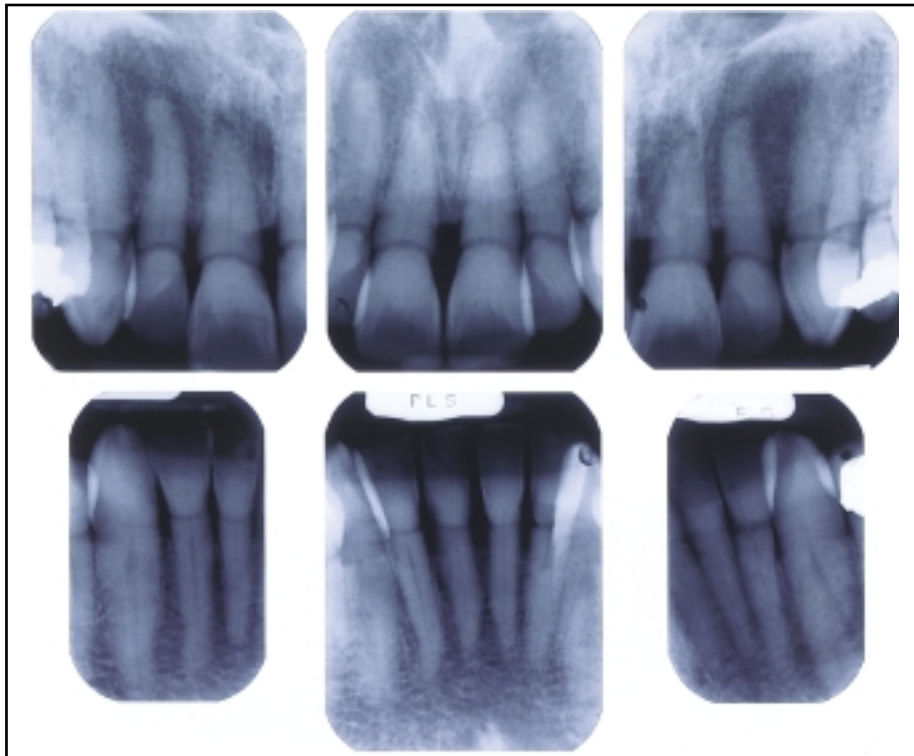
Intra-oral periapical radiographs.
